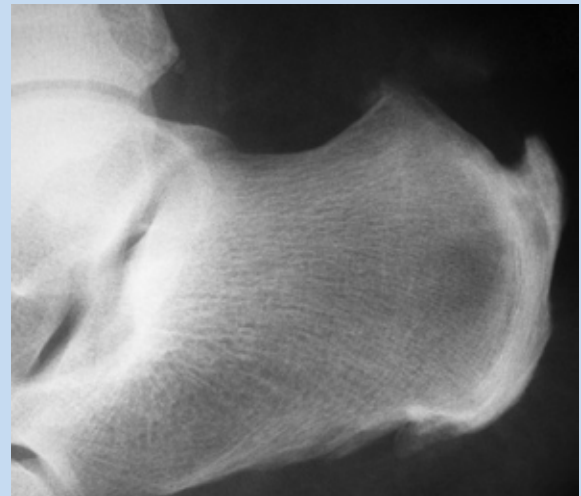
Lateral radiograph of calcaneus showing a Haglund lesion.
